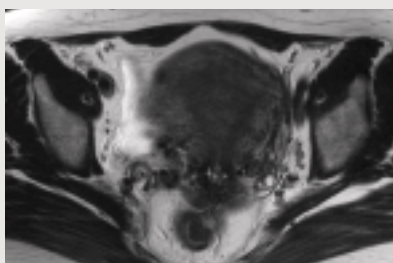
T1-weighted image
